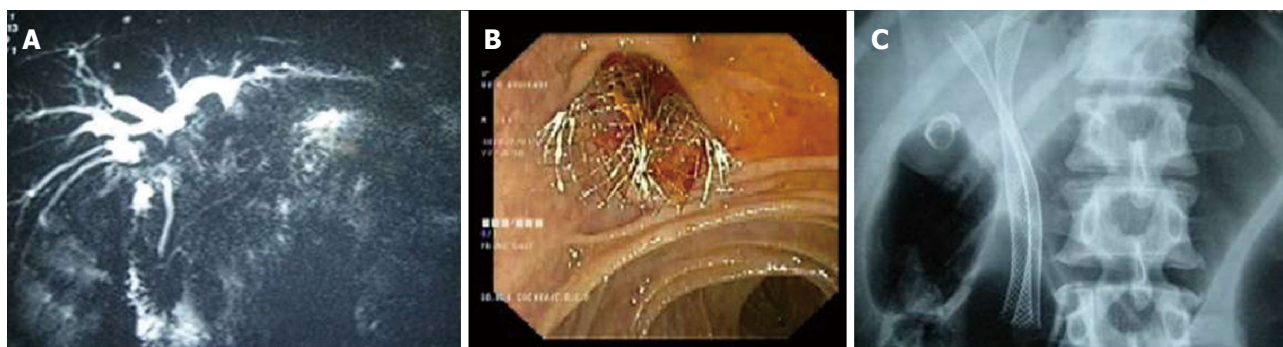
Two metal stents placed side by side in a Type II Bismuth hilar cholangiocarcinoma. A: Magnetic resonance cholangiopancreatography showing the stricture; B: Endoscopic view showing two metal stents placed side by side; C: X-ray showing two parallel stents with proximal ends in the right or left ductal systems.
